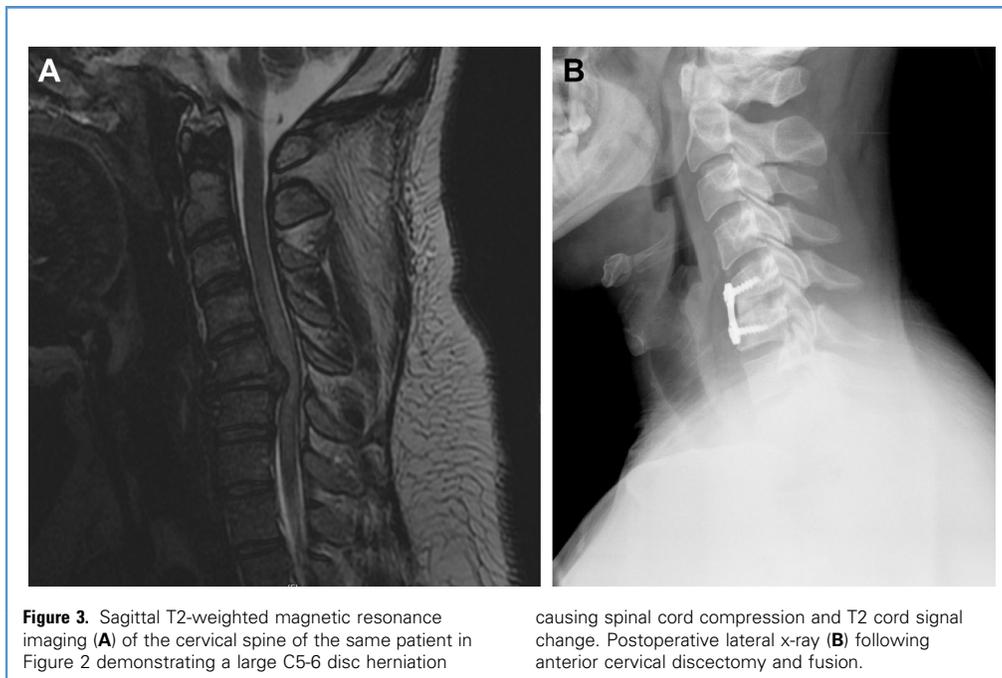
Sagittal T2-weighted magnetic resonance imaging (A) of the cervical spine of the same patient in Figure 2 demonstrating a large C5-6 disc herniation
